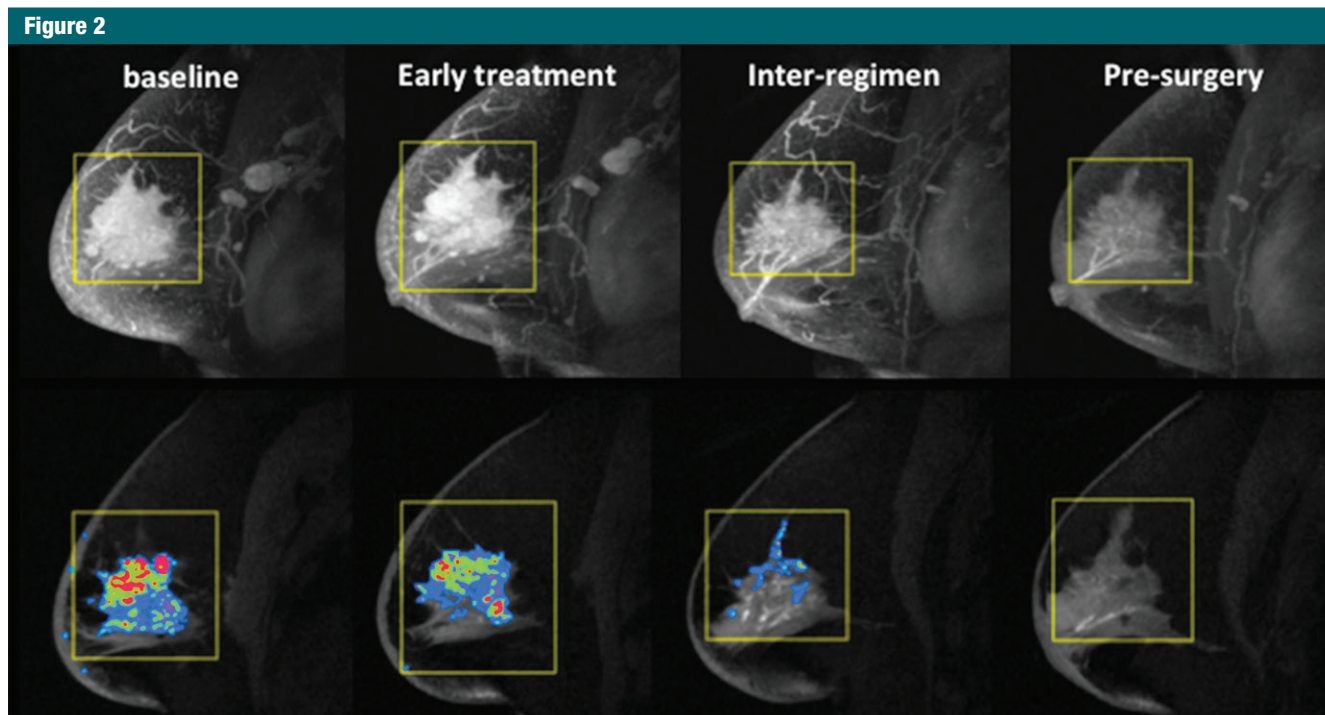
Longitudinal MR images and FTV maps. Maximum intensity projection images (top row) and corresponding FTV maps (bottom row) for a patient with an excellent clinical response and disseminated residual disease. FTV measurements were 48.5 cm³, 35.4 cm³, 5.6 cm³, and 0 cm³ for baseline, early treatment, inter-regimen, and presurgery time points, respectively (shown from left to right).
